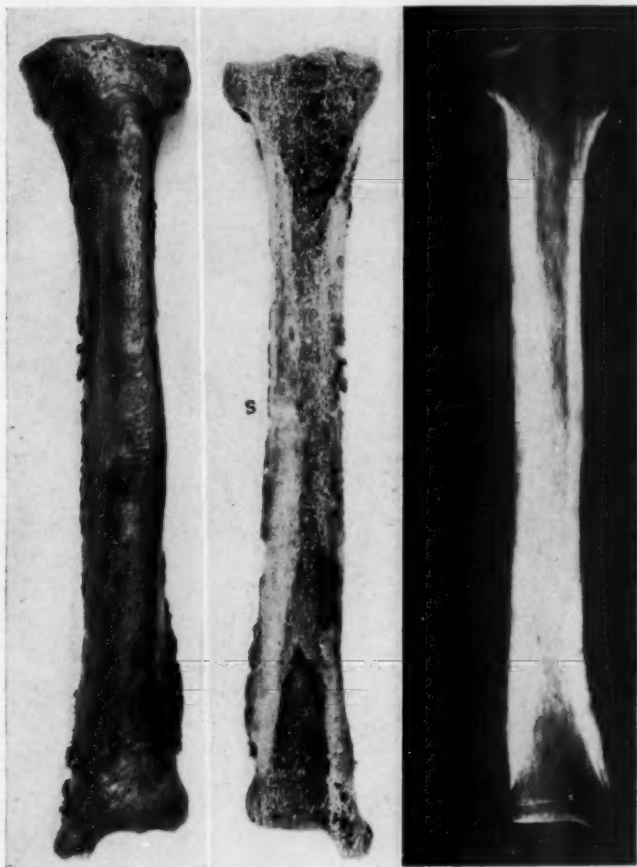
The left tibia (anterior surface), the vertical section and the roentgenogram, Field Museum 169664.
